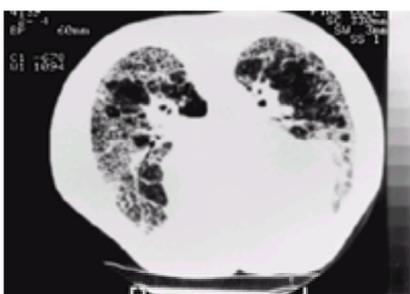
Prone, high-resolution CT through the lower lobes. There is a reticular pattern in a subpleural distribution representing established fibrosis in a case of systemic sclerosis.
